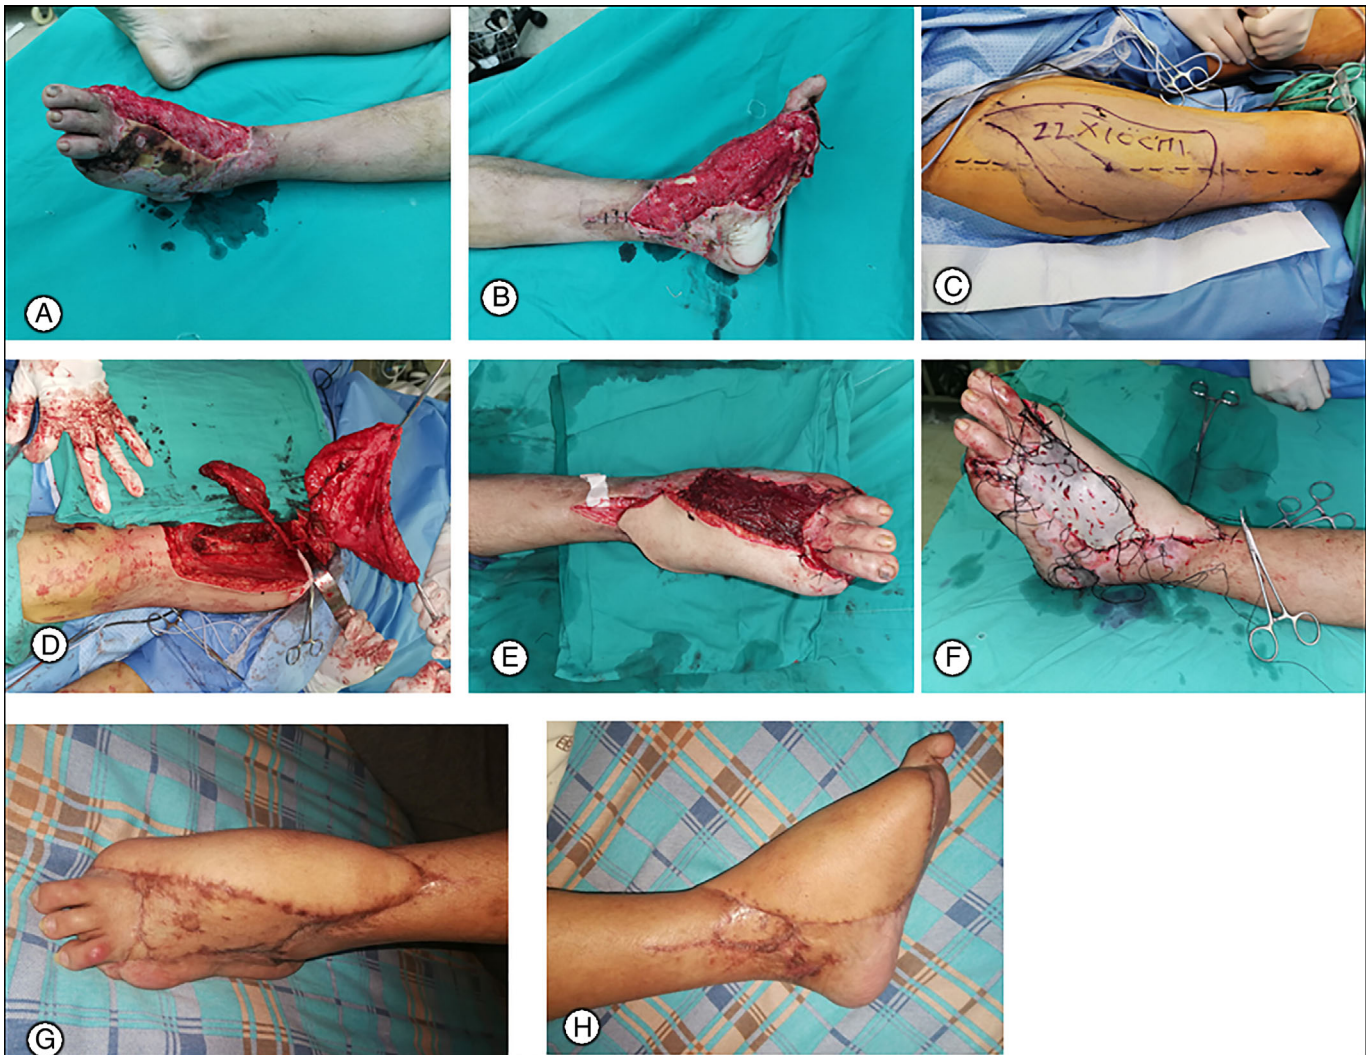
Case 1. A 24-year-old female patient with open fracture of distal tibia and fibula complicated with soft-tissue contusion caused by a traffic accident underwent debridement, fracture reduction and internal fixation in a local hospital and wound closure. At postoperative 1 week, she was transferred to our hospital due to secondary ischemic necrosis of the skin at the injured site. The larger deep wound was repaired with the chimeric anterolateral thigh perforator flap. (A, B) Appearance photos and anteroposterior and lateral radiographs of ankle joint. (C, D) After the debridement of the distal necrotic lesions of the ankle, tendon, tibia and internal fixator were exposed, with a total wound area of approximately 20 cm × 14 cm. (E, F) The chimeric anterolateral thigh perforator flap were designed and cut out. (G) The skin flap and muscle flap were arranged in a fan shape to cover the wound surface, the vascular pedicle at the donor site was anastomosed with the anterior tibial artery and vein, and the surface of muscle flap was covered with negative pressure. Postoperative microsurgical therapies, such as anti-inflammation, anti-spasm and anticoagulation, were performed as needed. (H, I) At postoperative 5 days, negative pressure on the muscle flap was removed. Blood oozed from the muscle flap. Full-thickness skin grafting was performed and the skin grafting site was covered by vacuum sealing drainage. (J) At 1 week after skin grafting, all flaps and skin grafting sites survived. (K, L) At postoperative 6 months, the flap and skin grafting site on the muscle flap had excellent appearance and no deep infection occurred.
